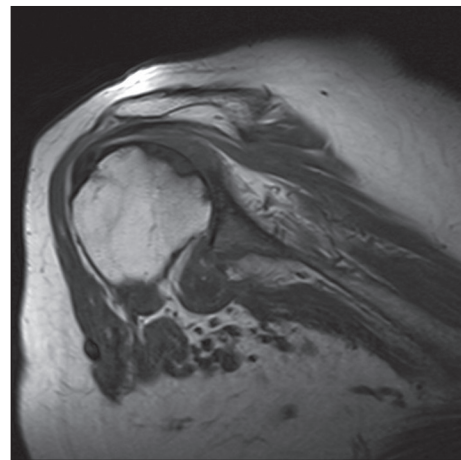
T2 weighted coronal MRI scan showing abnormal increased signal in the distal supraspinatus tendon which appears to be thinned and compressed with no definite tear or tendon retraction seen
